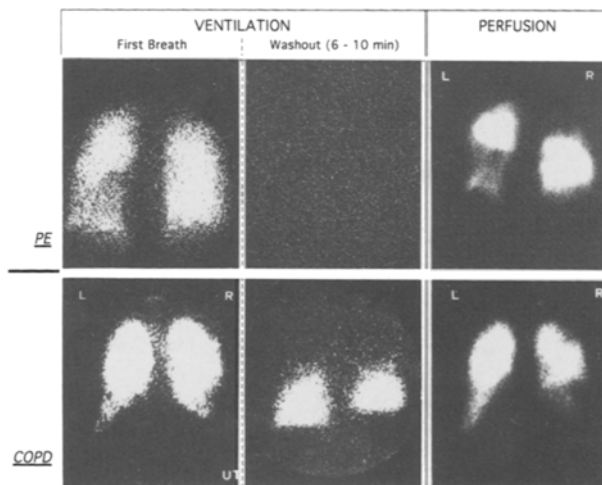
Ventilation and perfusion lung scintigraphy, analogous display (selections are given of representative images).
